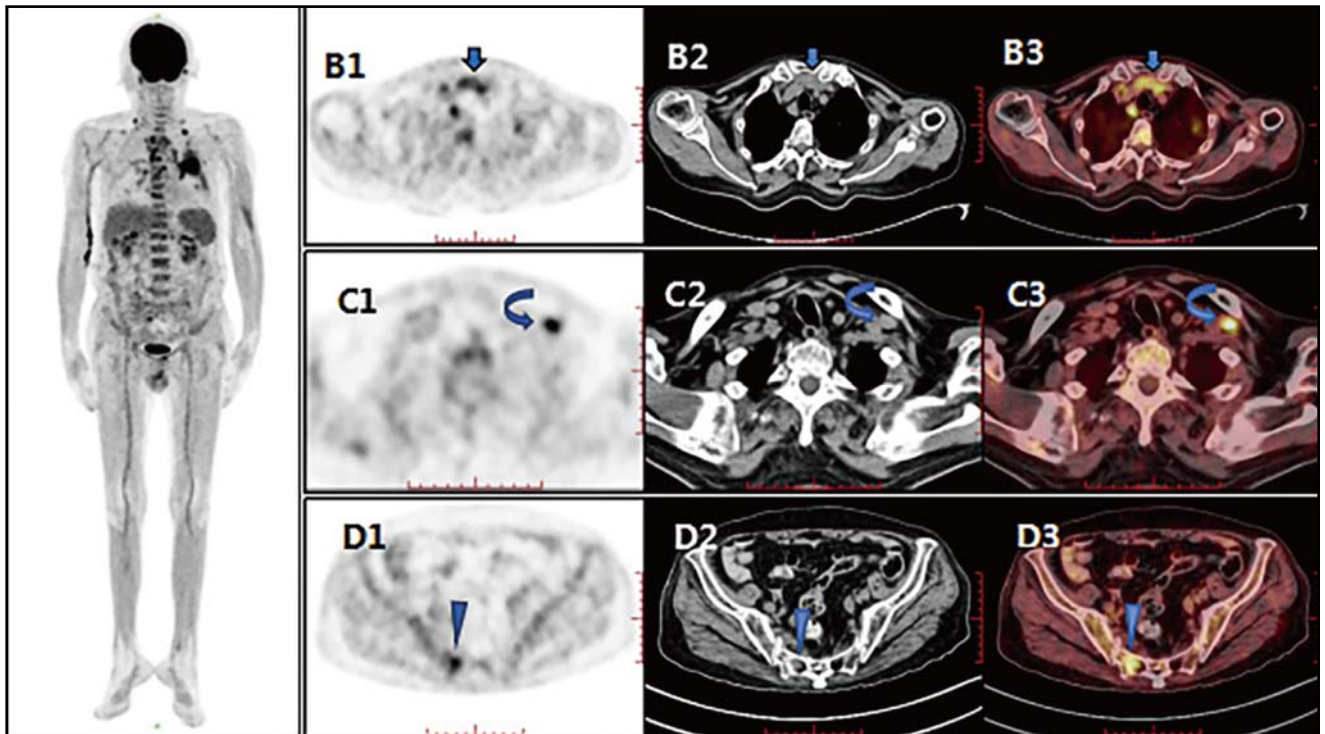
The results of PET-CT. B1-B3 showed the thymic tumor; C1-C3 showed the left supraclavicular lymph node metastasis; D1-D3 showed the sacral metastasis involving the right second sacral foramen. PET-CT: positron emission tomography-computed tomography.
